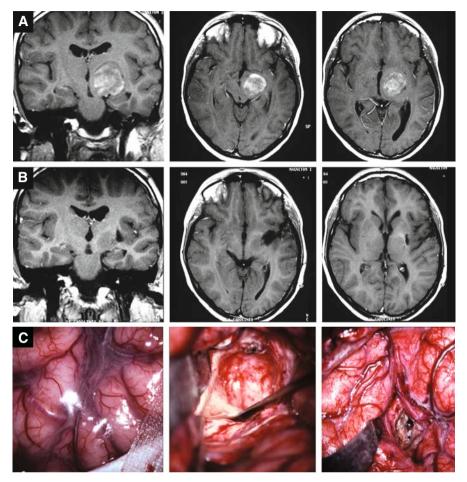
15-year-old female presenting with motor deficits in the right upper limb with worsening hand dystonia; even the leg on the same side showed vague, but similar symptoms. Pre- (A) and post-operative (B) gadolinium enhanced MR images show a focal mesencephalo-thalamic tumor that was totally removed through a pterional transsylvian approach (C). The patient showed a progressive improvement. She writes well despite a persistent slight dystonia of the hand
